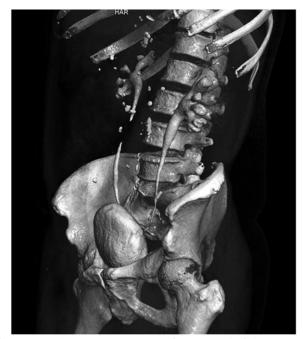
Follow up CT urogram after removal of the ureteral stent 30 days post repair.
